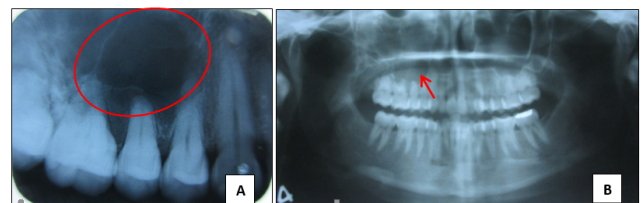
Radiographic presentation. (A) Periapical radiograph revealing well defined radiolucency from distal of 13 to distal of 16 with root resorption in relation to 14, 15 and 16. (B) OPG revealing similar findings along with missing teeth of all the third molars
